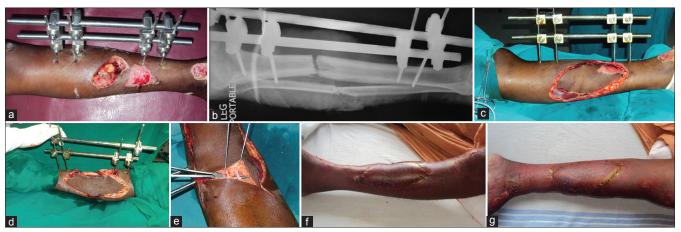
Case no. 42, flap with local risk factors and smooth healing) double flap for M 1/3 leg defect. Intraoperative views of a 28yr lady with RTA. (a) Open fracture Leg. (b) R leg – X-ray. (c) and (d) Medial and lateral flaps of 8 × 12 cm size incised. (e) Technique of preserving superficial vein and nerve while dividing deep fascia. (f) and (g) Well settled flaps at 6 weeks after transfer as type II A flap
